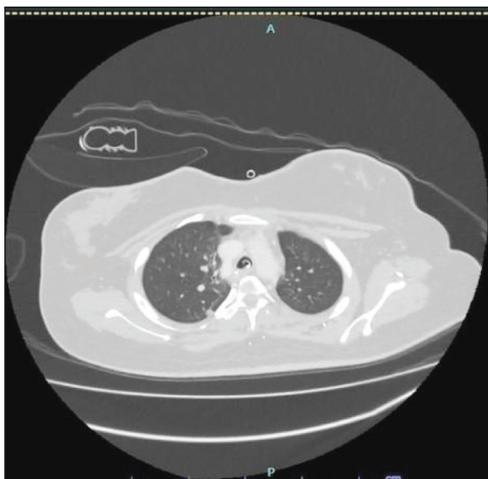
A computed tomography scan in axial view showed an in-situ endotracheal tube that occupies the whole tracheal lumen, which makes it difficult to assess presence of the complete tracheal ring.
